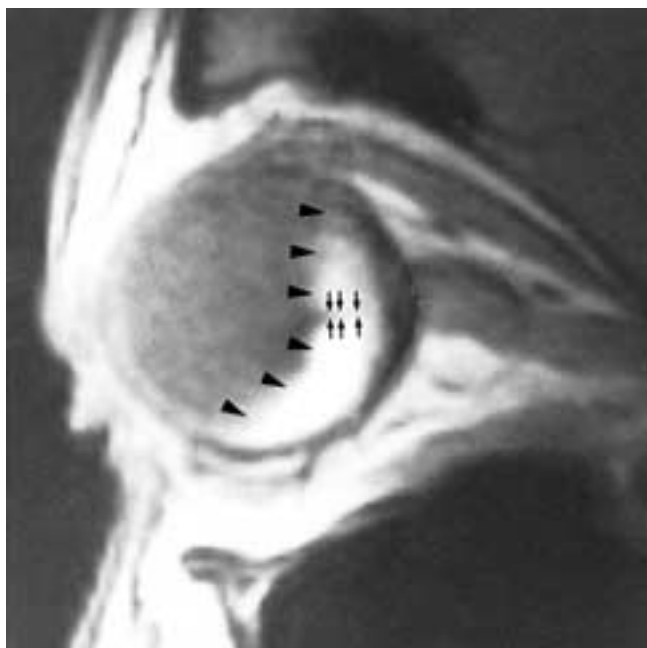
Retinal detachment. Sagittal PW MR image shows a detached retina (arrowheads) with characteristic folding of the retinal leaves (arrows) toward the optic disc.
